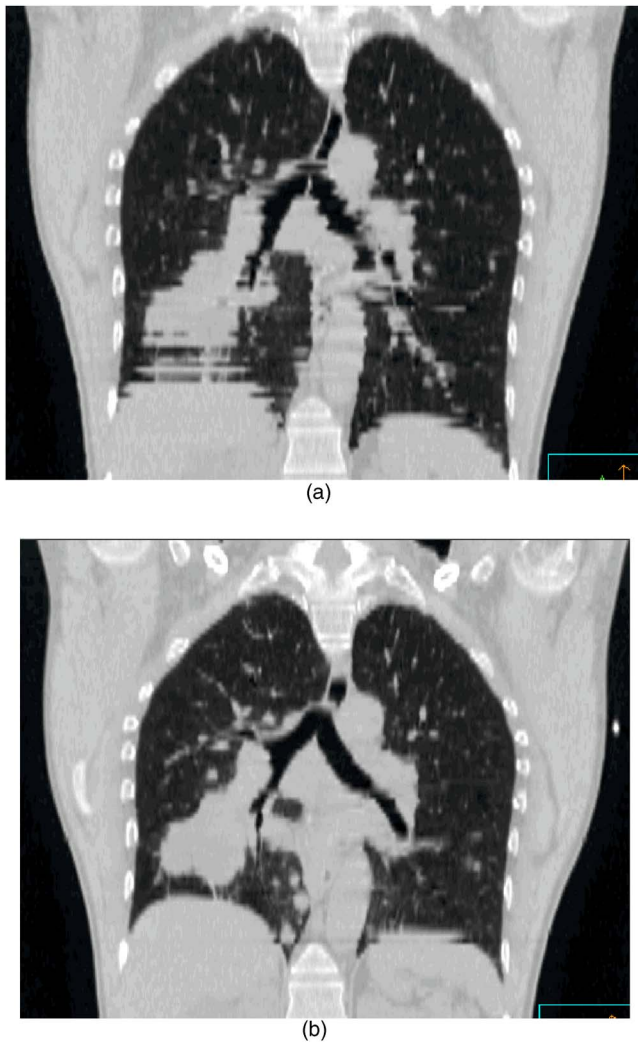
Coronal views of CT scans of the same patient taken (a) during free breathing (FB) and (b) with respiratory gated scanning at exhalation. From Ref. 140.
